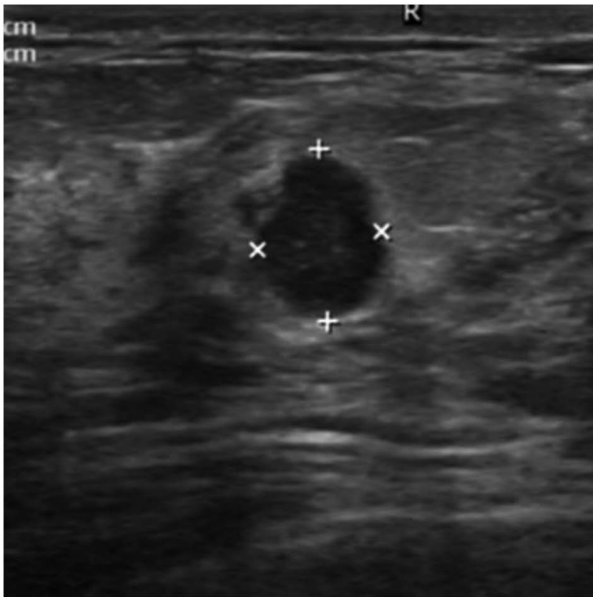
A 38-year-old woman without PND who underwent bilateral breast ultrasonography. Post-operative pathology diagnosed as ADH in right breast. US demonstrates a low echoic tumor in right breast, the lesion size is 1.00x0.71 cm, the lesion distance from nipple is 0.73 cm.
